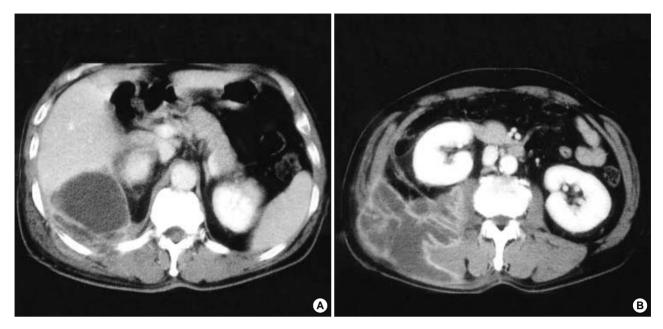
Contrast-enhanced computed tomography images (A, B) show a 10-cm sized multi-septated cystic lesion with rim-like enhancement involving the right back muscles extending into the retroperitoneum.
